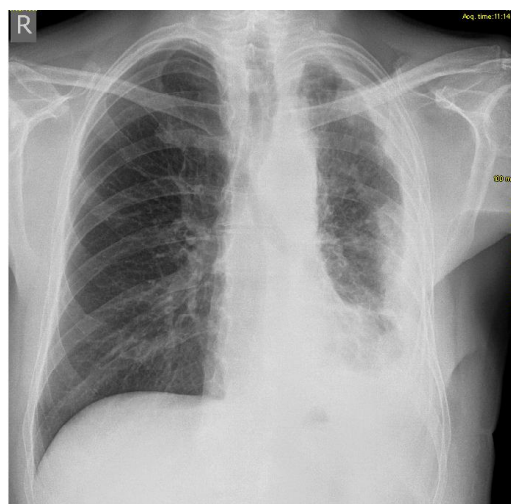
Initial chest radiograph
